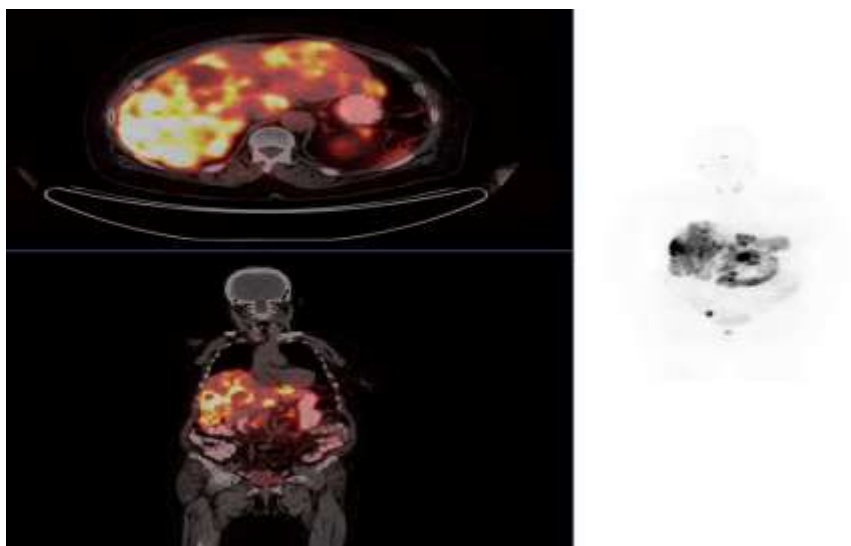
A 72-year-old female patient was diagnosed as Grade 1 WDNET metastases with Ki 67 1% as a result of biopsy performed on the detection of metastatic lesions in the liver in routine imaging. Primary focus could not be detected with routine imaging.  $^{68}\text{Ga}$ -DOTA TATE PET/CT imaging revealed that multiple metastatic lesions showing intense somatostatin receptor expression in the liver, and a lesion showing dense somatostatin receptor expression, which could be compatible with the primary focus, in the anterior wall of the middle part of the rectum, and a focus compatible with the pelvic metastatic lymph node was detected.
